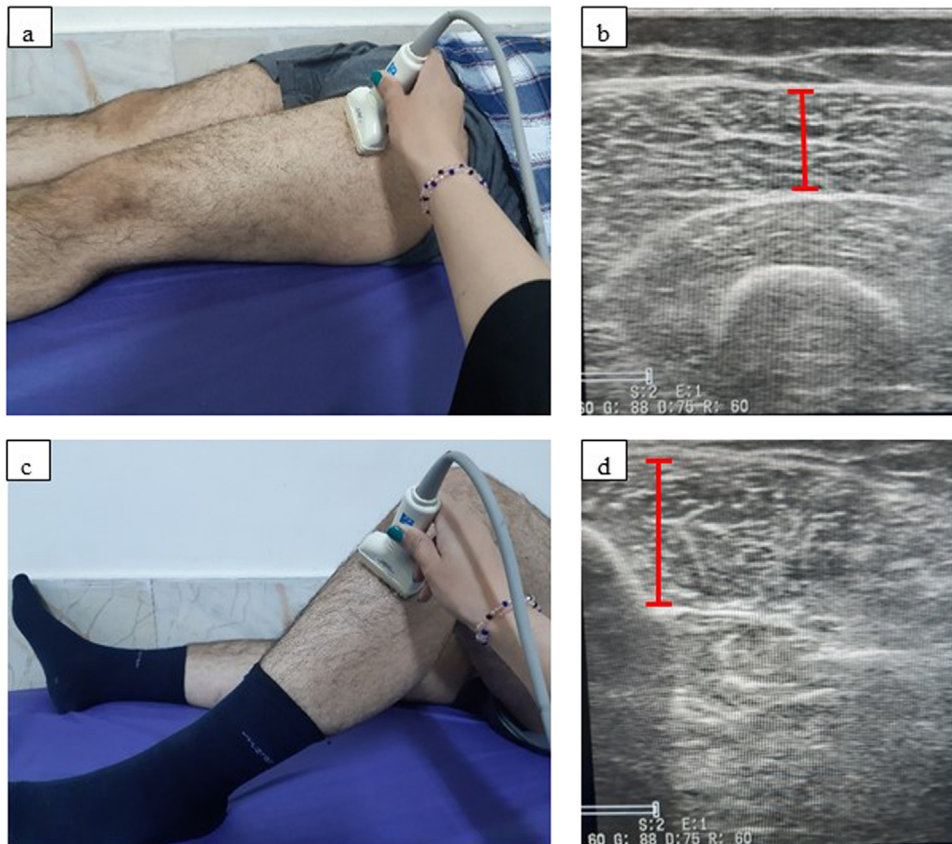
Position of the participants for measuring the RF muscle mass (A), ultrasound measurement of the RF muscle thickness (B), position of the participants for measuring the TA muscle mass (C), and ultrasound measurement of the TA muscle thickness (D). RF, rectus femoris; TA, tibialis anterior.
